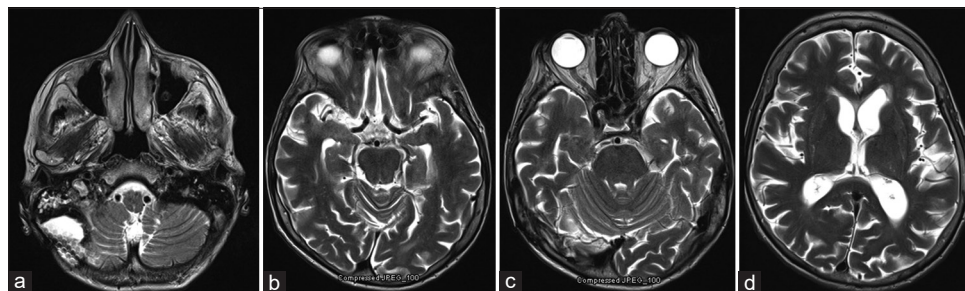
Three-month magnetic resonance images obtained at the time of the follow-up visit. (a-d) Respectively, caudal to rostral axial T2-weighted imaging sequence revealing resolved pneumocephalus.
